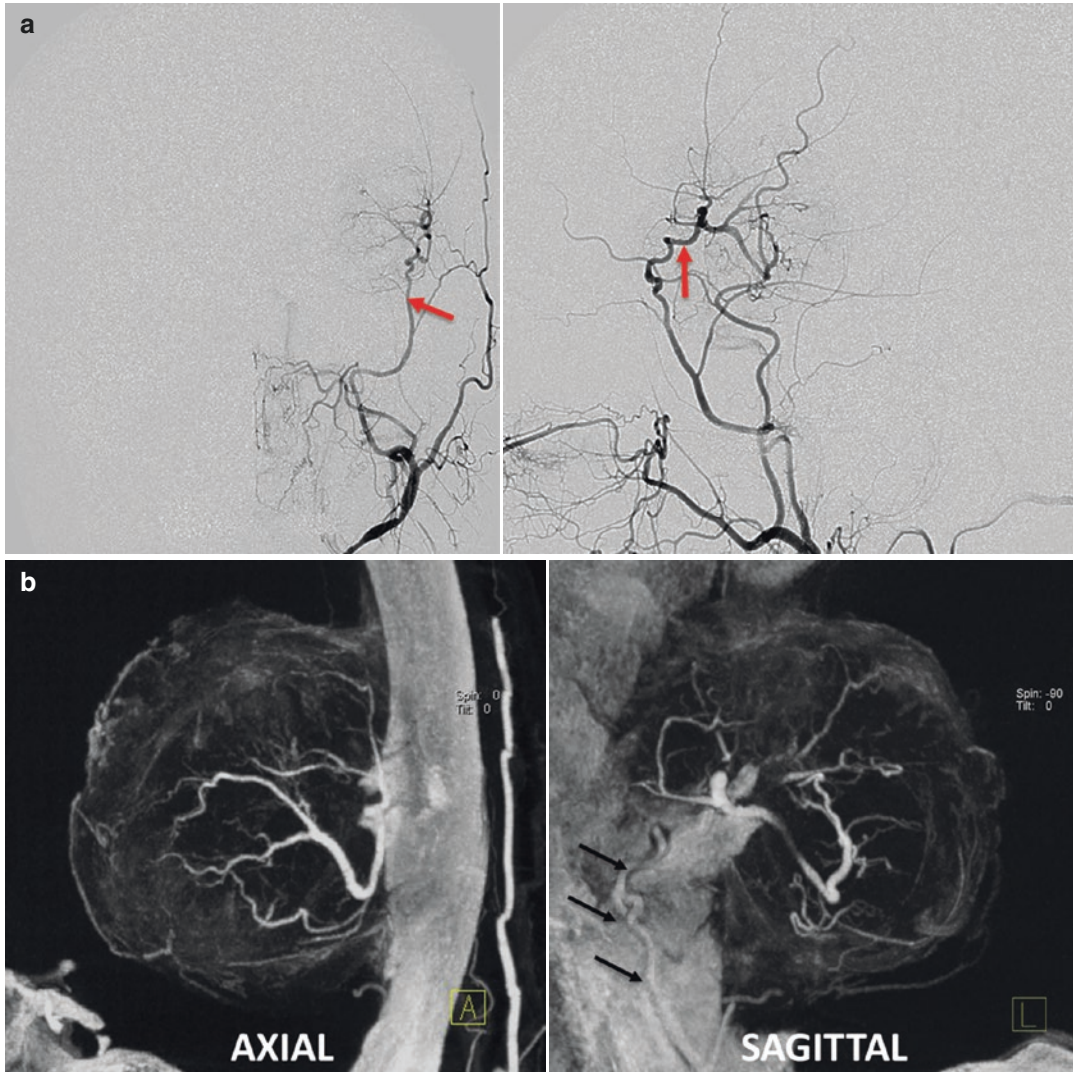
(a) AP (left) and lateral (right) 2D-DSA projections of an external carotid artery arteriogram showing the vasculature to a left frontal meningioma. The blood supply, derived from the middle meningeal artery (red arrow), is clearly seen as a series of tiny arteries radiating into the tumor. (b) Multi-planar [axial (left) and parasagittal (right)] reconstructions from a CBCT
